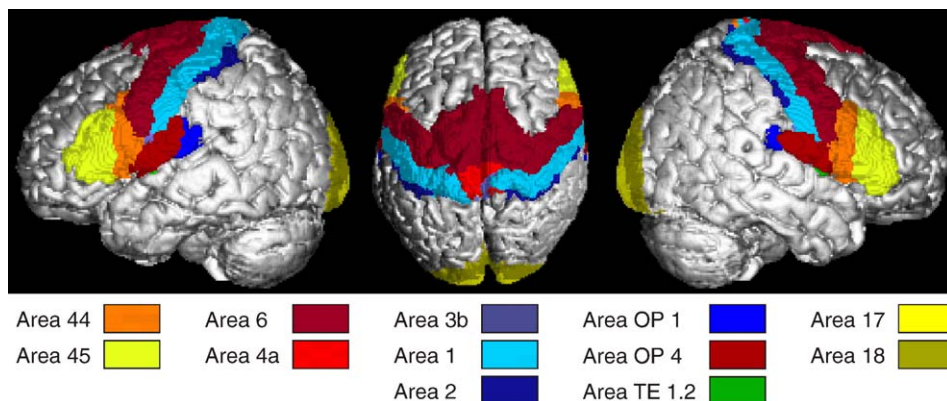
Surface rendering of the T1-weighted MNI single-subject template and the MPM (MPM) of all probabilistic maps of cortical areas published to date. Only the surface extent of the different areas is shown. (a) Lateral view on the left hemisphere, (b) dorsal view, (c) lateral view on the right hemisphere.
